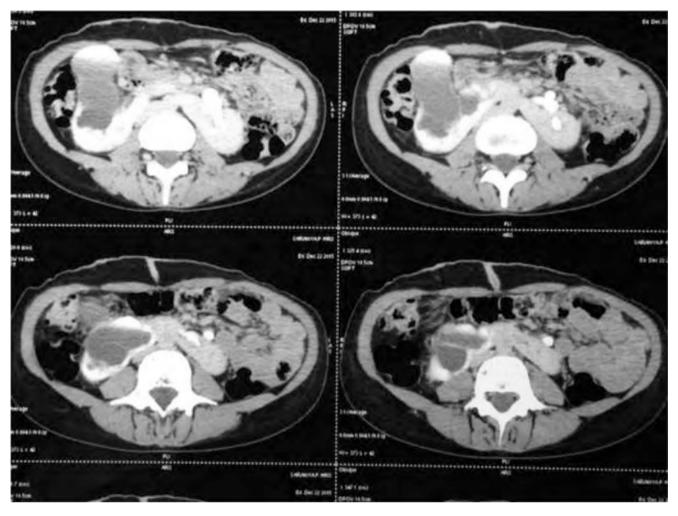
CT showing malrotated RT moiety with PUJ obstruction of a horseshoe kidney
